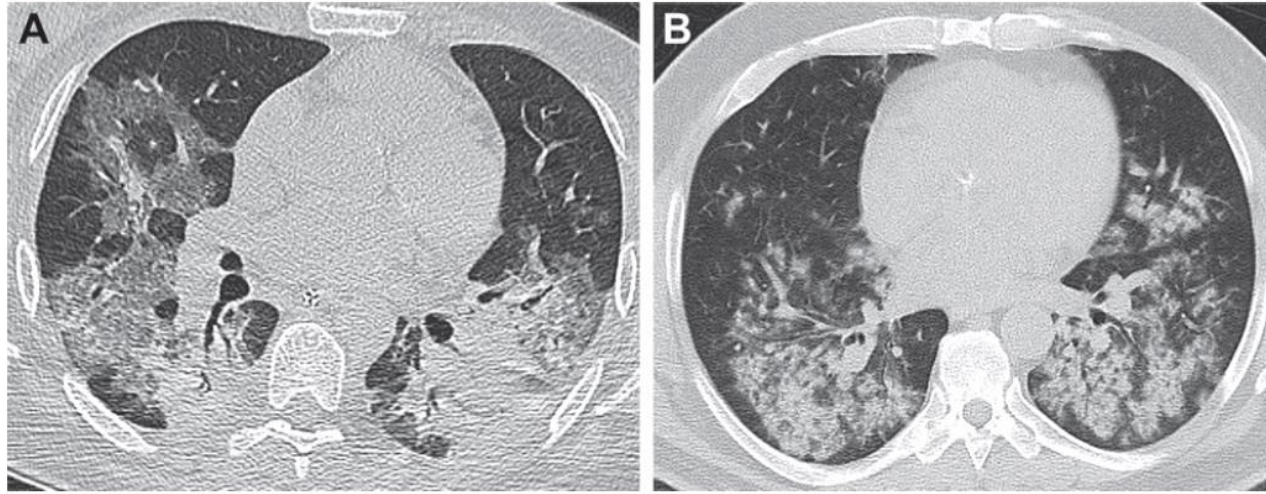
(A) Axial noncontrast CT image (lung window) in a 31-year-old woman with a cough and fever shows bilateral diffuse consolidation and ground-glass opacity. (B) Axial CT image in a 57-year-old woman with GPA and hemoglobin descent shows diffuse and extensive bilateral ground-glass opacities and consolidations, with sparing of the subpleural lung. Diffuse alveolar hemorrhage was confirmed at bronchoscopy.
